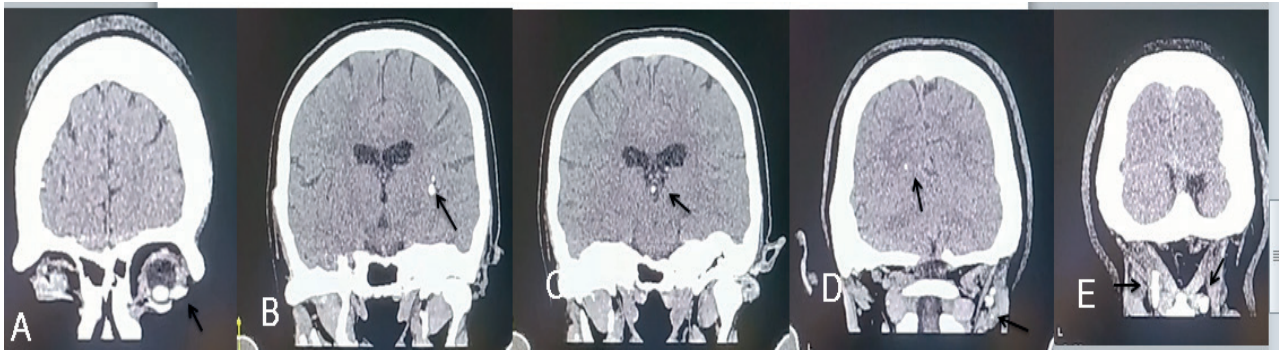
CT scan of the head, coronal reconstructions, brain parenchymal window. Small hyperdense images, calcific density in relation to calcifications (arrows). A: ocular. B and D: brain parenchymal. C: intraventricular. D and E: cervical soft tissue
